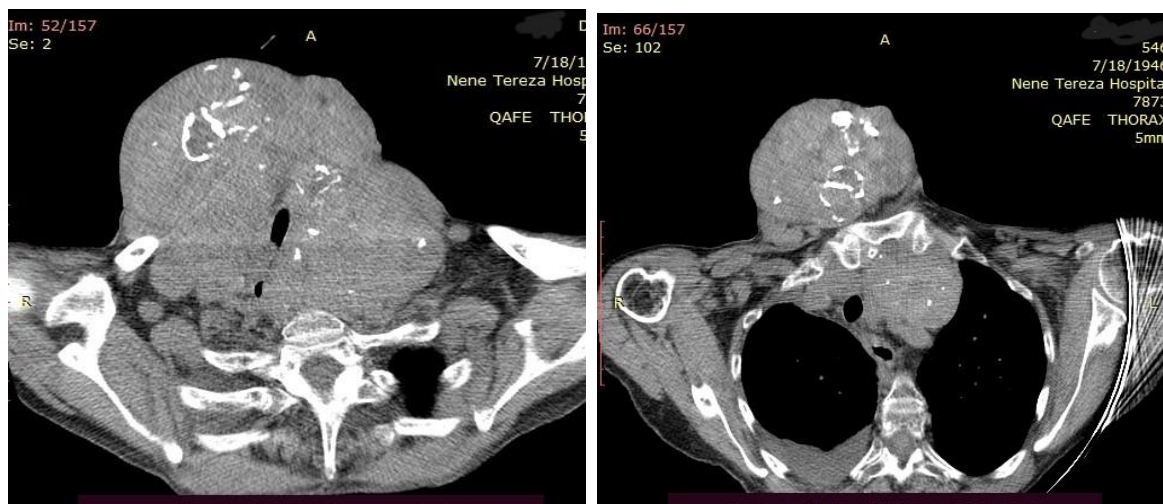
(a,b): CT scan of thyroid gland.
